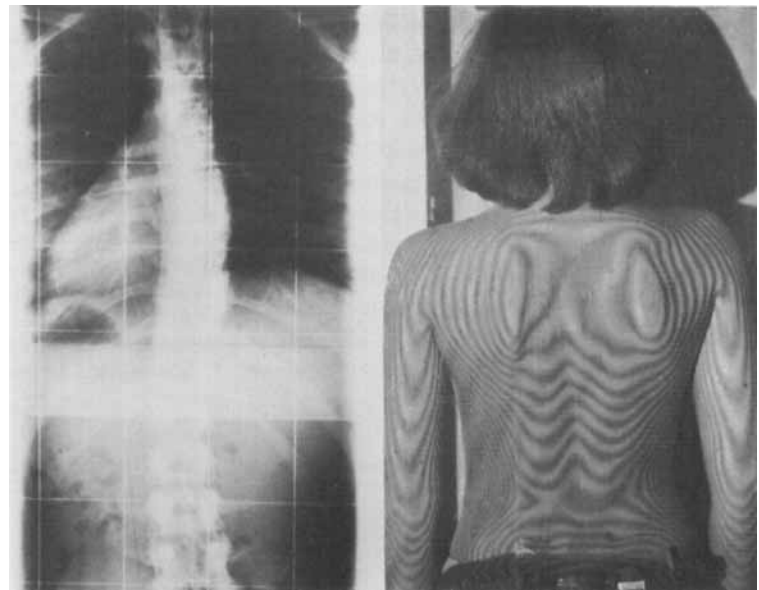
X-ray of a double curve in a 15-year-old girl and the symmetric moiré picture of the same girl.
